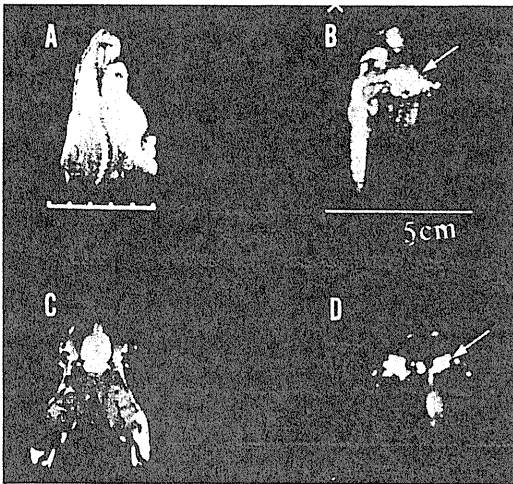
麻酔導入後, 1.75%の enflurane 麻酔 60 分経過時のラット頭部の  $^1\text{H}$  (図 1-A,C) および  $^{19}\text{F}$  MRI (図 1-B,D) 示す, いずれも field echo 法で, 繰り返し時間 300 ms, エコー時間 10 ms である. 前者および後者のマトリックスサイズはそれぞれ  $256 \times 256$ ,  $128 \times 128$  である. 図 1-A,B は側方から見, 図 1-C,D は腹側から背側を見た像である. いずれも図の上方が rostral となる.  $^{19}\text{F}$  MR 信号は頸部背側および頭部側方に著明で,  $^1\text{H}$  MRI との対比より前者は脂肪組織で, 後者は唾液線の脂肪組織が主体 (矢印) と考えた. 図中の横線はおのおの 5 cm に対応している.
